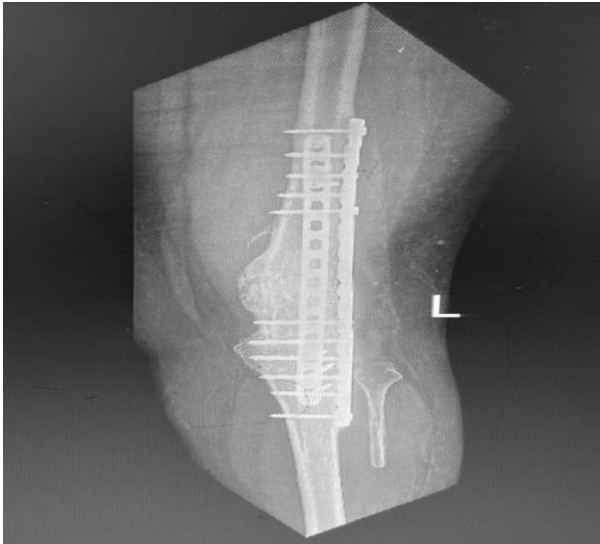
Immediate post op X-ray of bilateral lower limb with revision arthrodesis.
